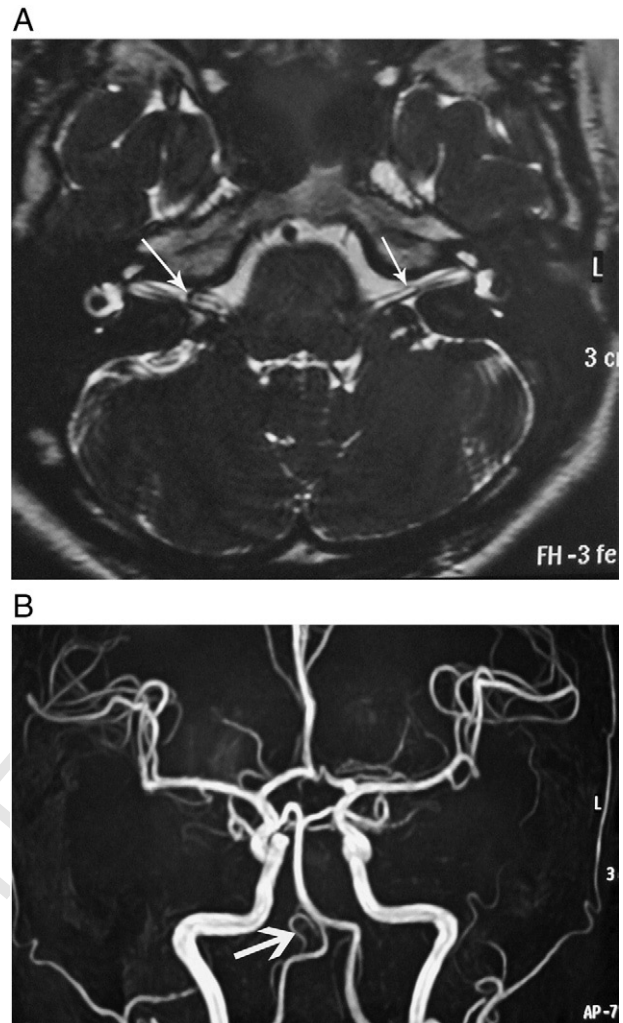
(A) Bilateral IAAs were observed on high-resolution thin-slice 3D T2-weighted MRI using driven equilibrium pulse sequence. Type IIB loop-type AICA/PICA entering into the IAC with contact to the vestibular nerve (large arrow). We also observed a type IB nonloop AICA/PICA entering into the left IAC (arrow) in a 40-year-old woman with right-sided hearing loss, occasional dizziness, and tinnitus. (B) The right loop-type AICA entering into the IAC was clearly observed on MRA obtained with 0.8-mm thin-slice original images.
